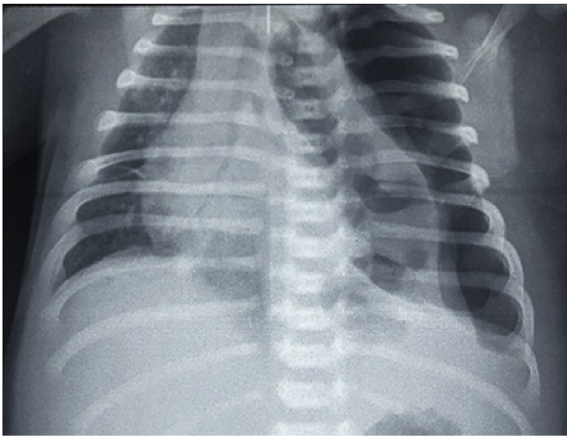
Plain film of the chest. Left hypertensive pneumothorax.
